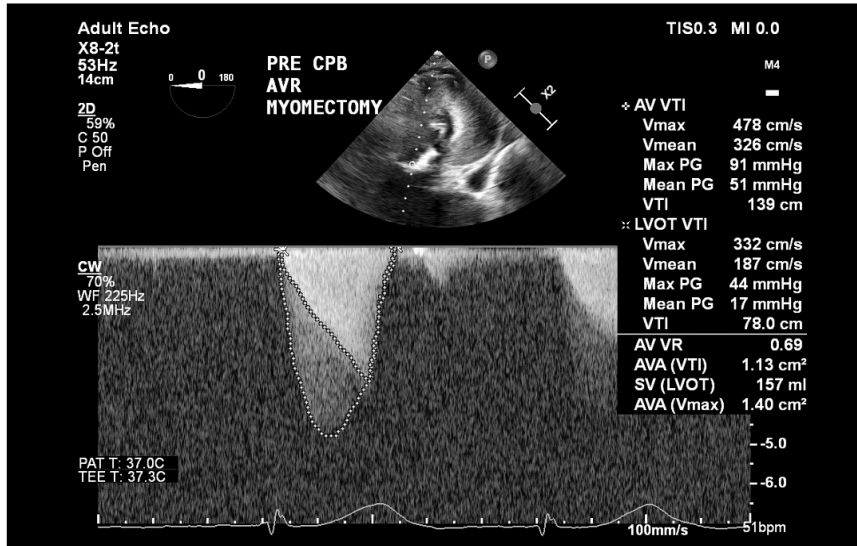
Parabolic spectral Doppler pattern of AV stenosis is seen parallel and partially overlapped with the late-peaking dagger-shaped spectral Doppler pattern of LVOTO.
